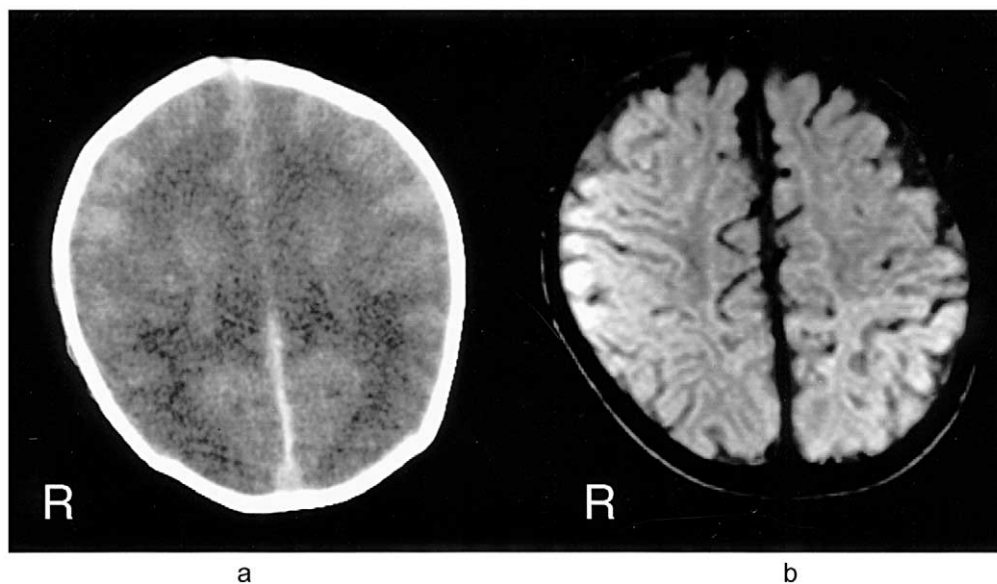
CT and MRI findings in case 3. (a) CT on the 18th day of life. A widespread low density area in the bilateral hemispheres was recognized. (b) A proton density image on MRI at 9 months of age demonstrated atrophy in the occipital region.
